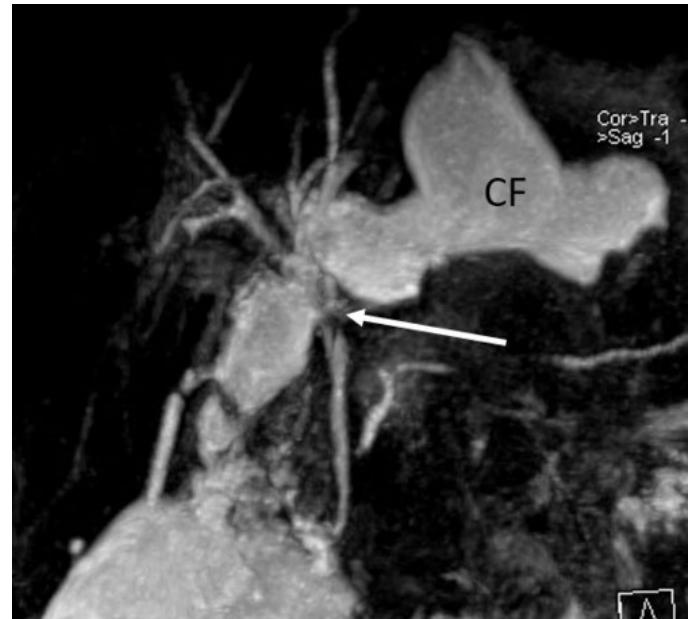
BDI detection by MRI. The open end of the left hepatic duct at the level of bifurcation is visible (white arrow). The massive collection of fluid (CF) in the subhepatic space coming from the left hepatic duct is visible.
